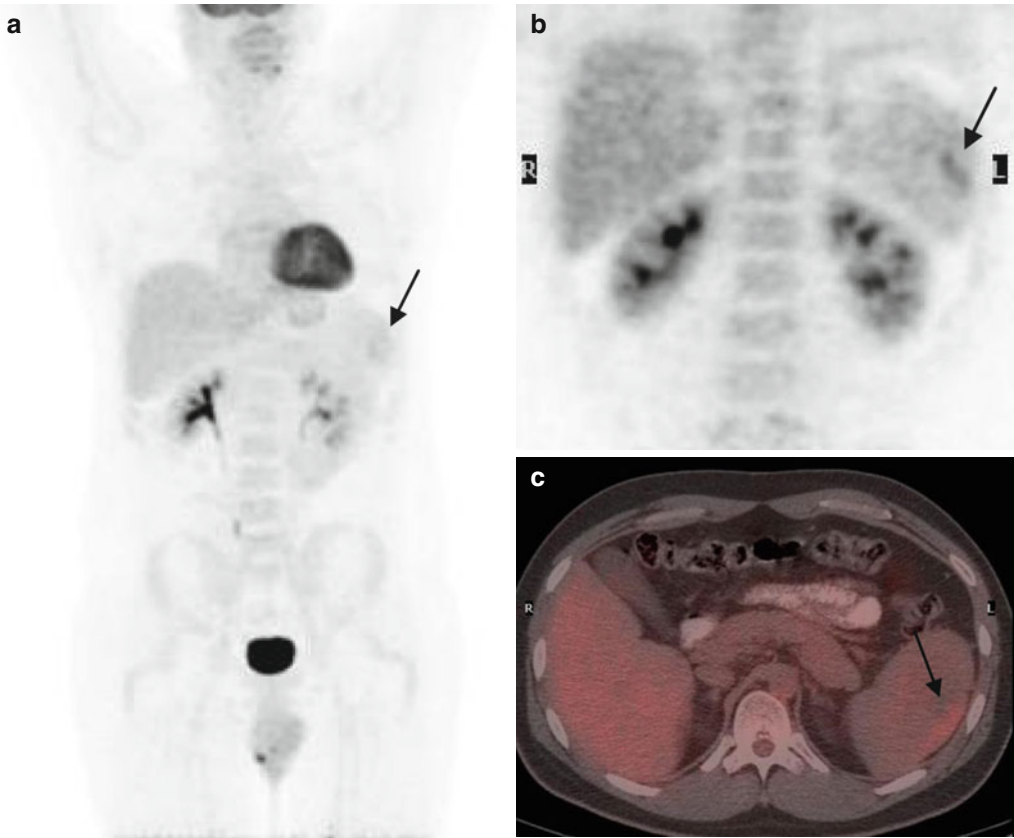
(a–c) MIP-PET and fused PET/CT- end of chemotherapy: Mild FDG uptake at a spleen lesion (*arrows*)
